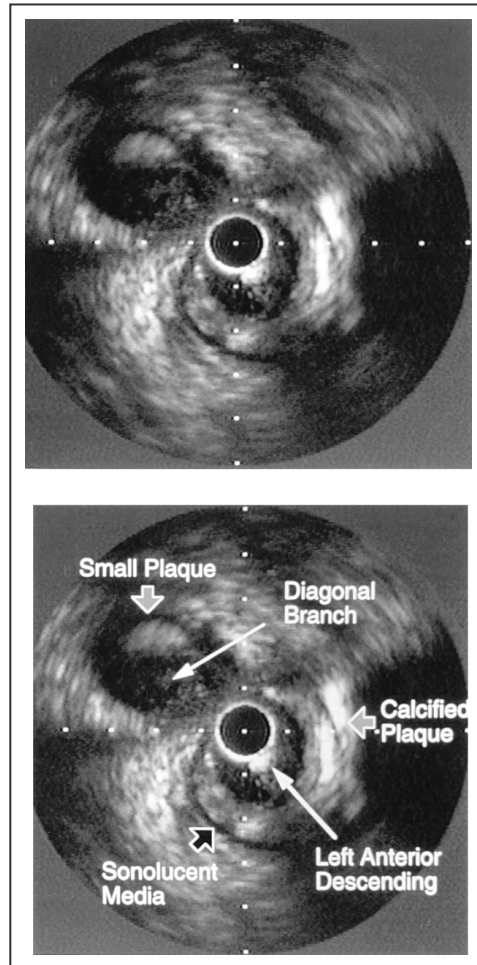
Ultrasound image of an eccentric, partially calcified atherosclerotic plaque in the left anterior descending artery at the bifurcation site of the major diagonal branch. A small eccentric plaque is seen in the diagonal branch opposite the flow-dividing wall.
